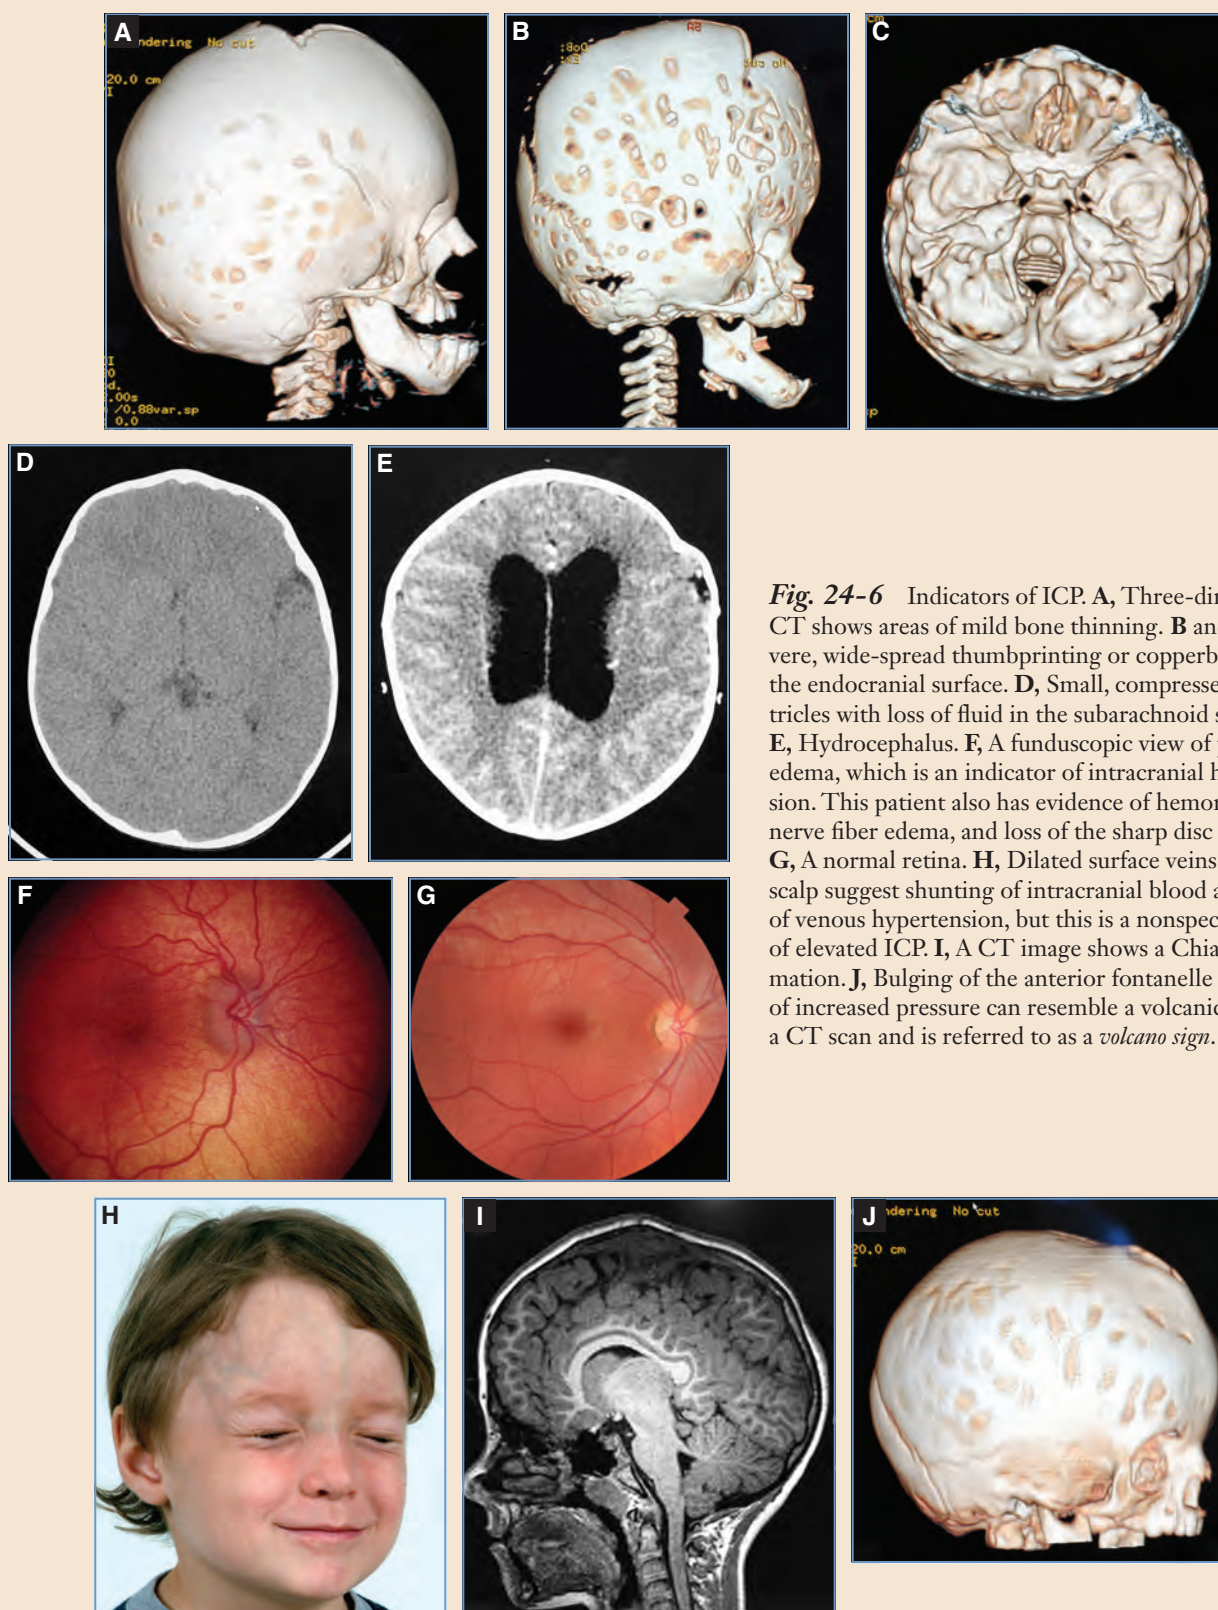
Indicators of ICP. A, Three-dimensional CT shows areas of mild bone thinning. B and C, Severe, wide-spread thumbprinting or copperbeating on the endocranial surface. D, Small, compressed ventricles with loss of fluid in the subarachnoid space. E, Hydrocephalus. F, A fundoscopic view of papilledema, which is an indicator of intracranial hypertension. This patient also has evidence of hemorrhage, nerve fiber edema, and loss of the sharp disc margin. G, A normal retina. H, Dilated surface veins on the scalp suggest shunting of intracranial blood as a result of venous hypertension, but this is a nonspecific sign of elevated ICP. I, A CT image shows a Chiari malformation. J, Bulging of the anterior fontanelle because of increased pressure can resemble a volcanic crater in a CT scan and is referred to as a *volcano sign*.
